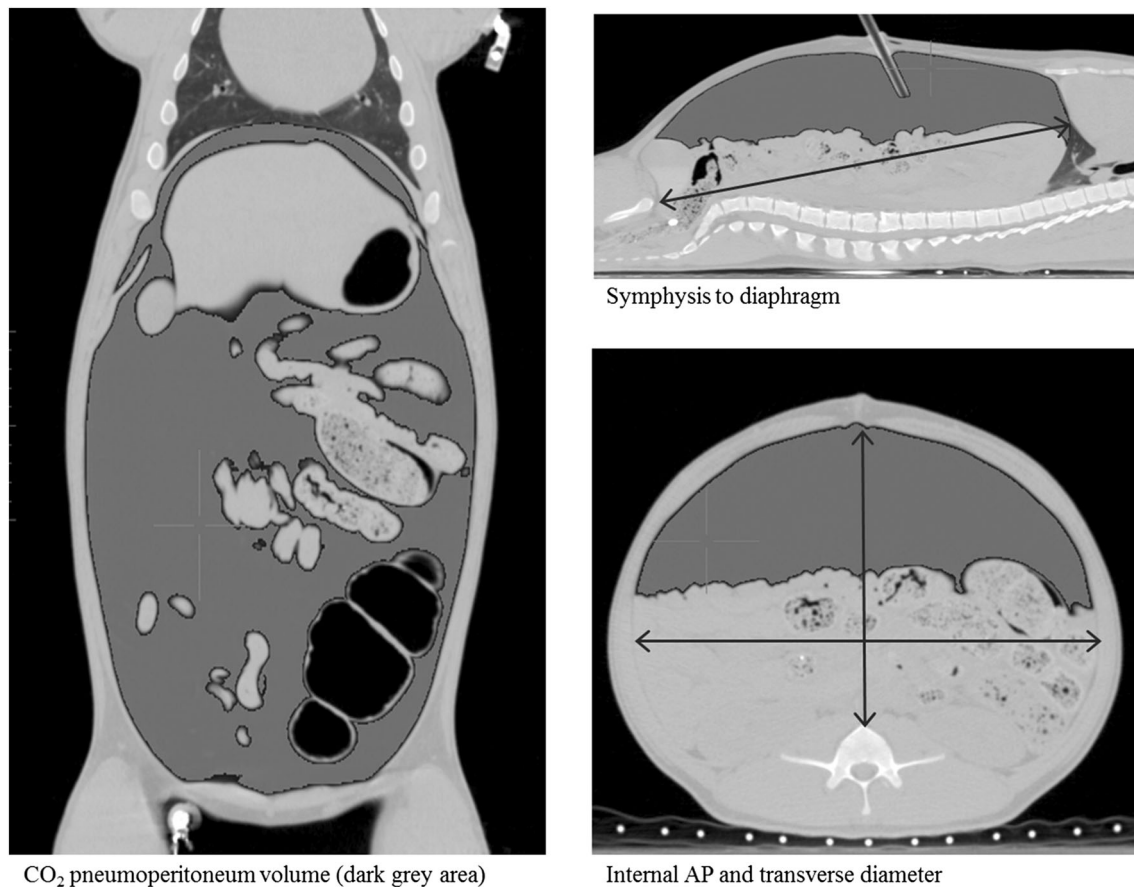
CT-images and reconstructions showing working-space dimensions. AP antero-posterior (anterior peritoneal lining to the anterior vertebral column)
